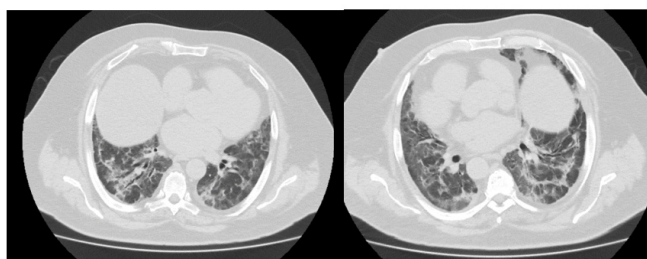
A 70-year-old male patient with COVID-19. The axial non-enhanced CT scan of the chest shows bilateral diffuse GGO associated with interlobar septal thickening, reticular opacity, and traction bronchiectasis.
